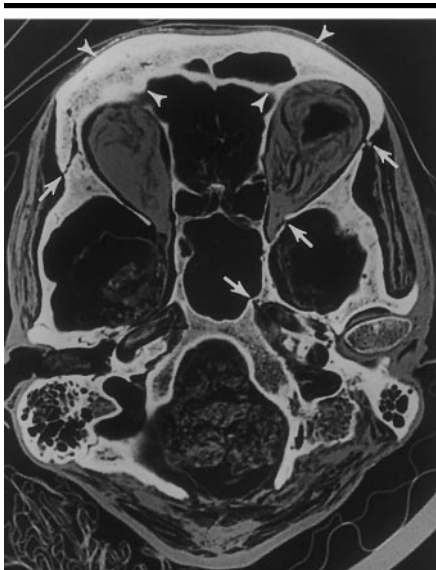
Transverse CT section through the orbits and foramen magnum (obtained on September 25, 1991) shows examples of multiple hairline fractures (arrows) in the facial bones and at the skull base. The fractures are consistent with the combined effects of freezing and thawing cycles and the weight of ice and snow. Note the thick frontal bone (arrowheads) and prominent supraorbital ridge.
